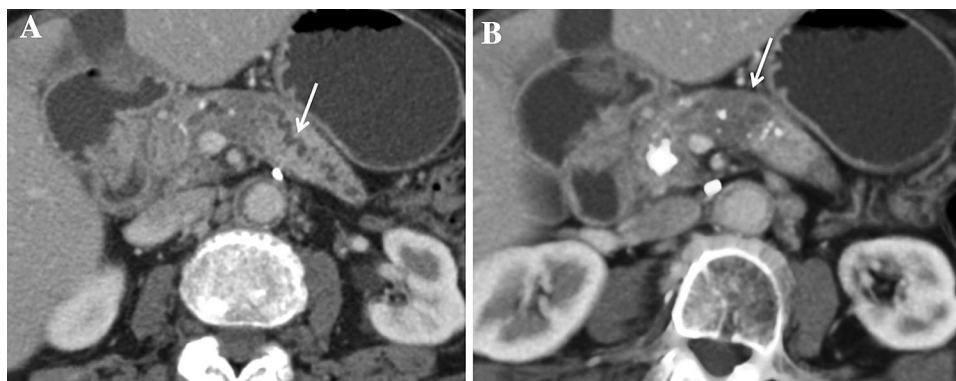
66-year-old woman with chronic pancreatitis. CT showed (A) a dilated main duct in the pancreatic tail (thin arrow) and (B) a hypoenhancing mass in the pancreatic body
